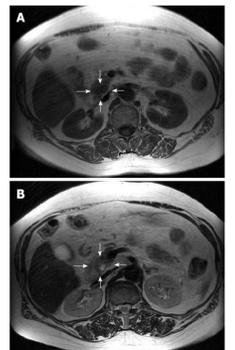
CT scan showing typical location of insulinoma<sup>7</sup>
